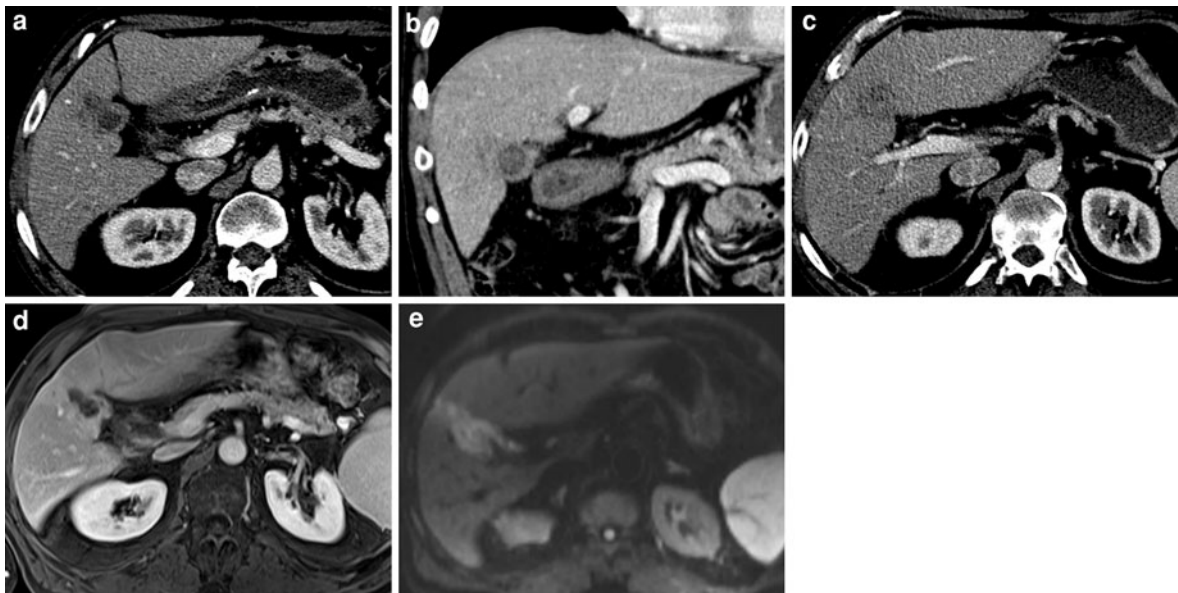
Gallbladder cancer mimicking cholecystitis. A 64-year-old patient is treated for lymphoma of the neck. He presented with mild fever and increasing pain of the right upper quadrant. US shows enlargement of the gallbladder wall without the Murphy sign. CT and MRI could not differentiate between chronic cholecystitis and cancer. Fine-needle aspiration was performed and confirmed malignancy. The tumor was
